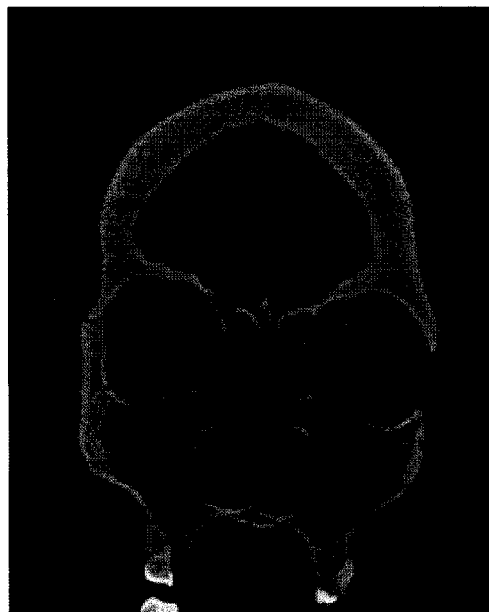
Maxillary sinuses as imaged using CT.
